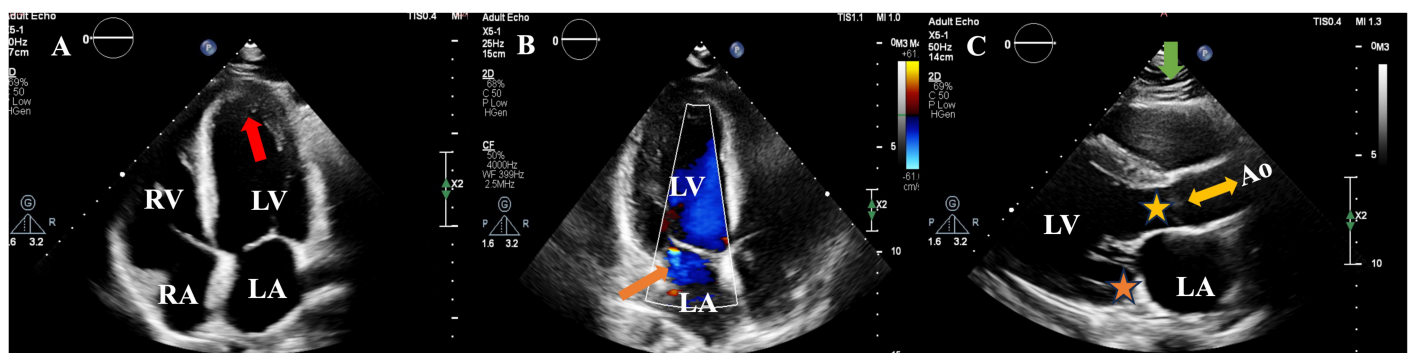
Transthoracic echocardiography images. (A) In the apical 4-chamber view, hypokinesia of the apical segment is observed (red arrow). (B) Color Doppler echocardiography demonstrates mild mitral regurgitation (orange arrow). (C) In the parasternal long-axis view, the aortic (yellow star) and mitral (orange star) valves appear normal, with no pathology detected in the ascending aorta (double-headed yellow arrow) or pericardium (green arrow).
